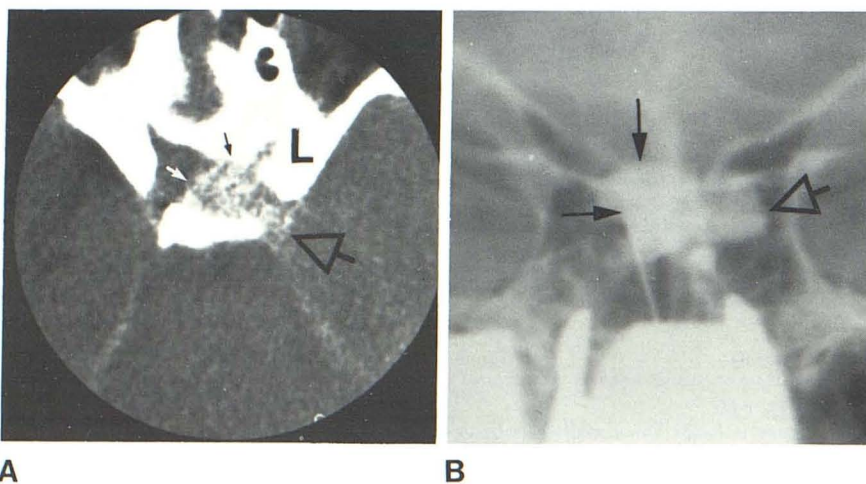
Parasellar extension. A, CT scan of pituitary adenoma performed during carotid injection of contrast medium (reprinted from [3]). B, Intraoperative demonstration of same tumor. Intrasellar (solid arrows) and parasellar (open arrows) components.
